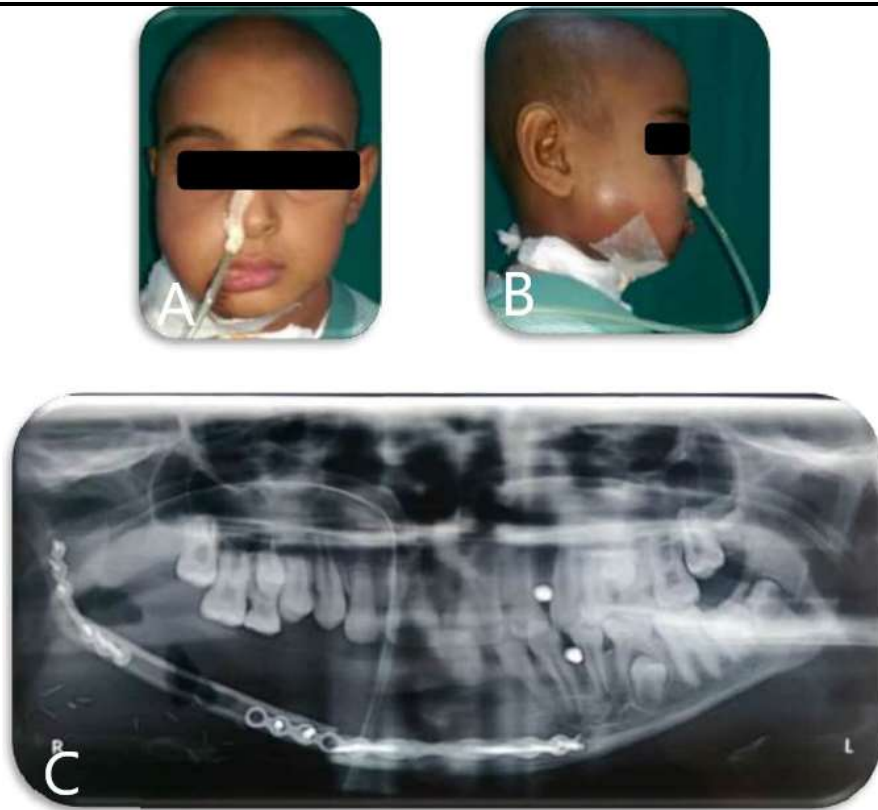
A, B, C- Post-operative clinical and radiographic images
